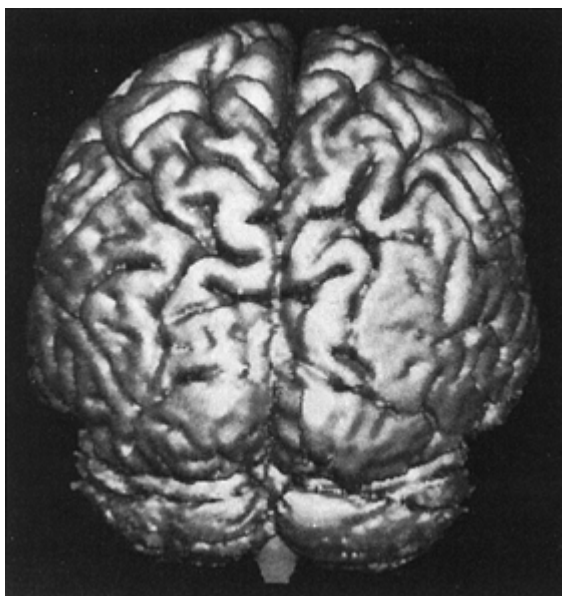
Posterior hemispheric three-dimensional volumetric re-cord rendering: A cortical dysplastic area is noted posterior parietal. This abnormality was not seen on standard magnetic resonance imaging studies.
